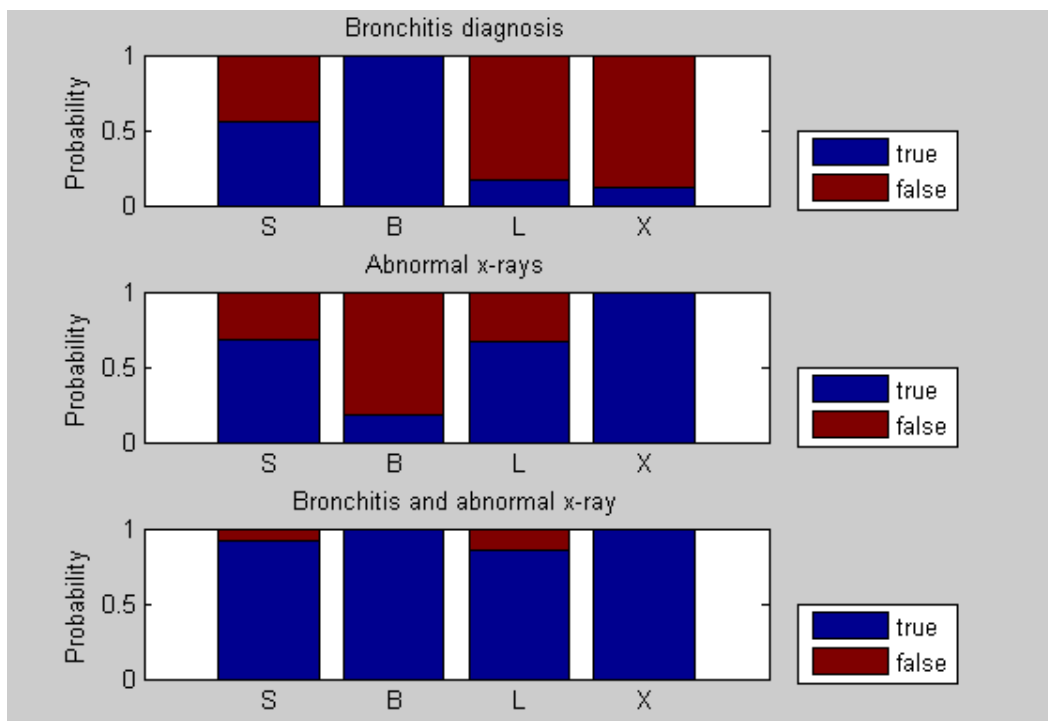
Bronchitis and abnormal X-rays
